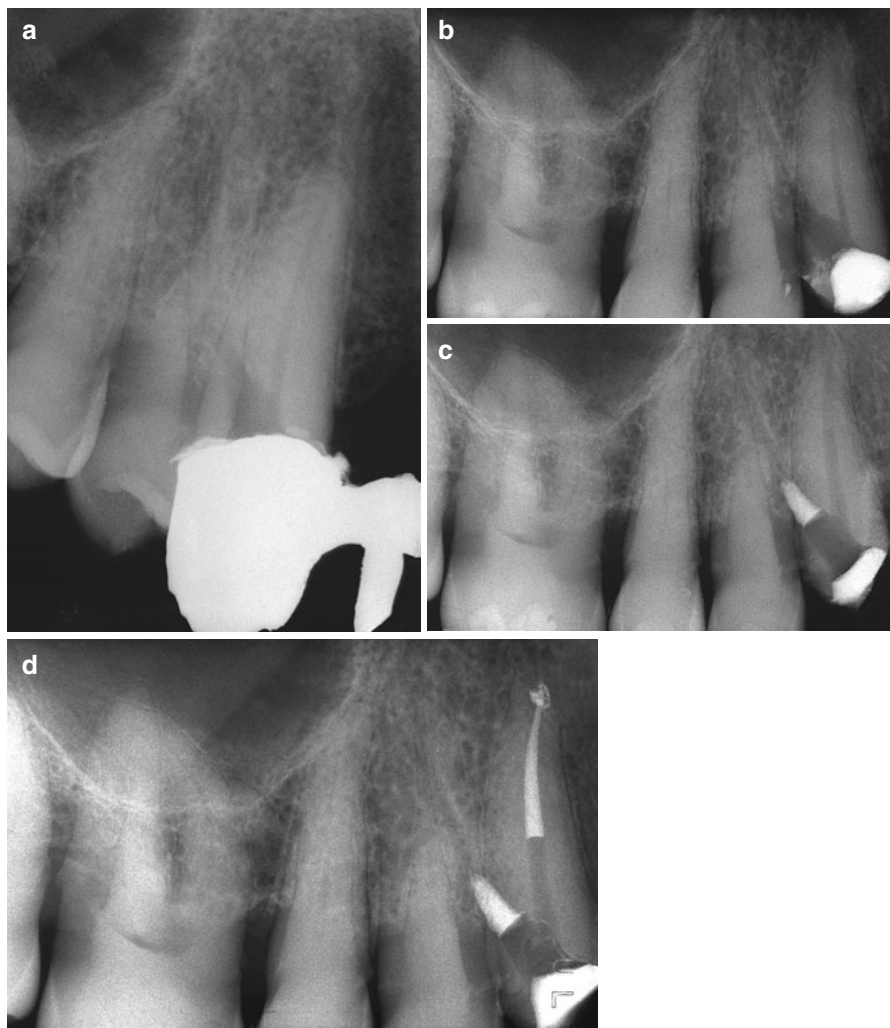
(a) A preoperative film of a maxillary cuspid with a perforation on the distal aspect of the coronal one-third. (b) The off-angle radiograph shows better the perforation. (c) The perforation has been repaired with MTA. (d) Postoperative radiograph
